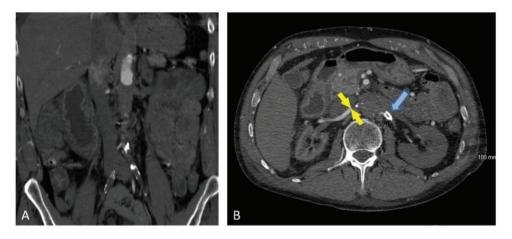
(a,b) Coronal and axial CT scan views demonstrating occlusion of the pararenal and infrarenal aorta and common iliac arteries. The proximal renal arteries are occluded bilaterally. The blue arrow points to previously placed left renal stent that is now thrombosed. There is flow in the right renal artery and branches of the left renal artery (yellow arrows). The left kidney is edematous and without enhancement. There is cortical enhancement in the right kidney.
